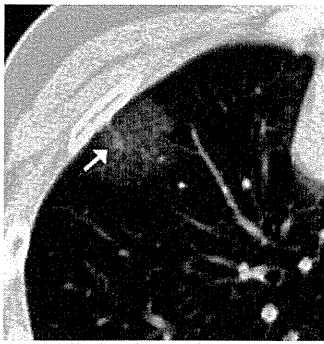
CT of nonmucinous minimally invasive adenocarcinoma. Axial 2-mm CT section shows a peripheral, predominantly ground-glass, part-solid nodule in the right upper lobe that includes a 4 × 3 mm solid component (arrow), which corresponded to invasion by pathology. CT, computed tomography.
